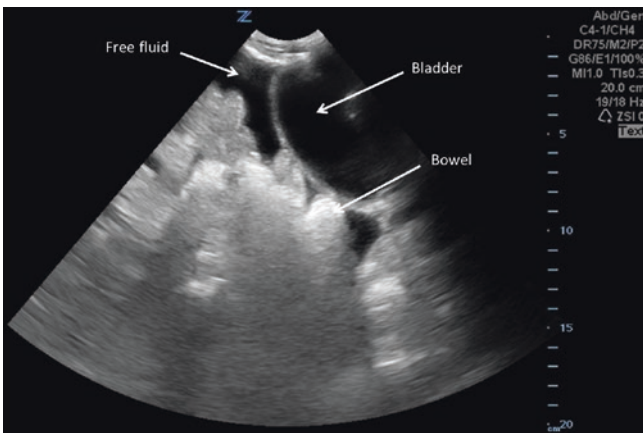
Ultrasound image of free fluid in the longitudinal plane of the pelvis. Pelvis with free fluid collecting in the rectovesical space. Image courtesy of Pimpa Limphan-udom
